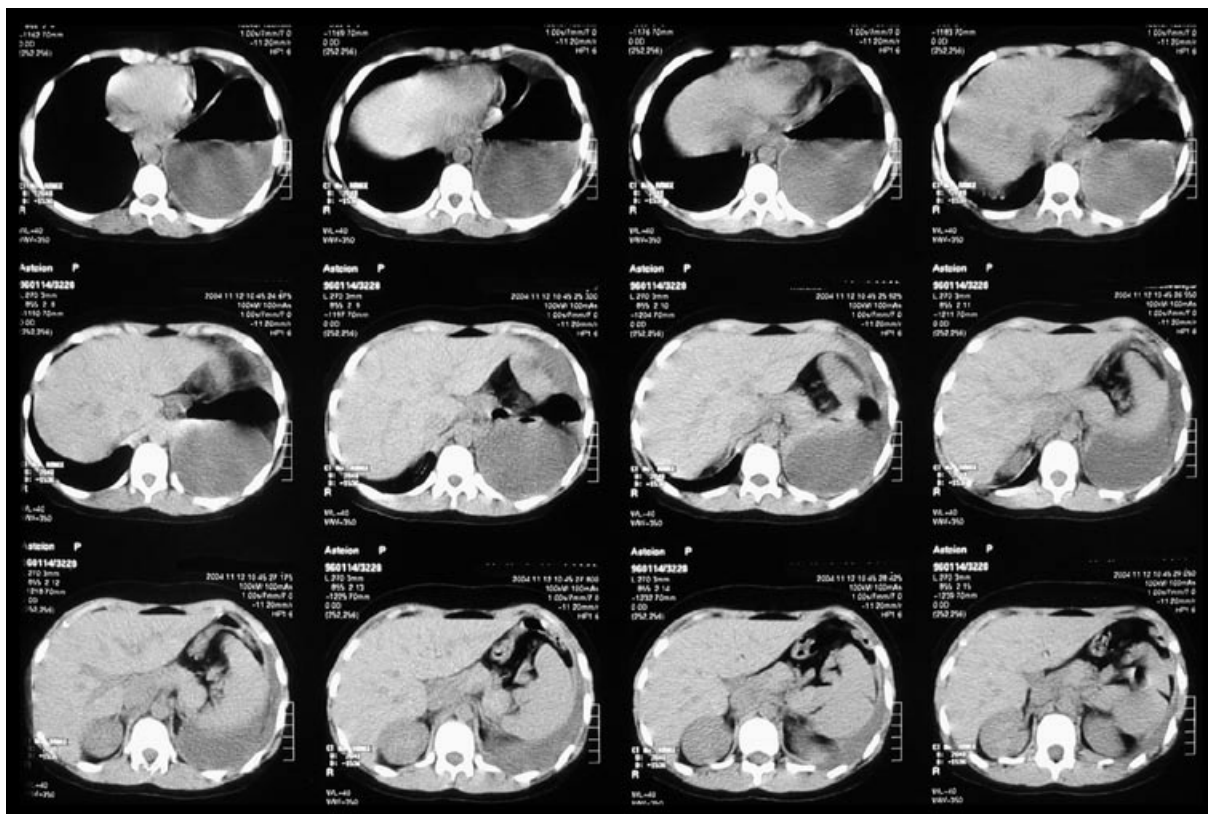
Abdominal CT: dislocation of the stomach and bowels to the left hemithorax.
